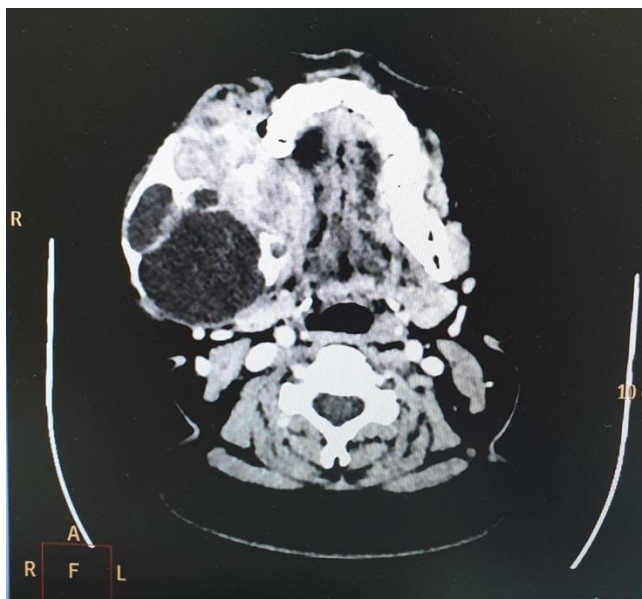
Axial computed tomography imaging showing a multilocular lesion with ramus expansion and destruction of surrounding bony structure.
